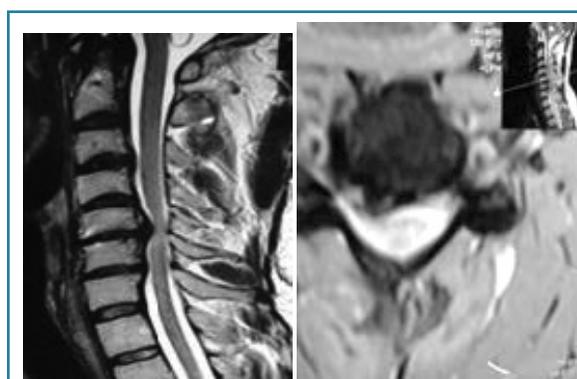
Preoperative MRI of cervical spine sagittal and axial view
